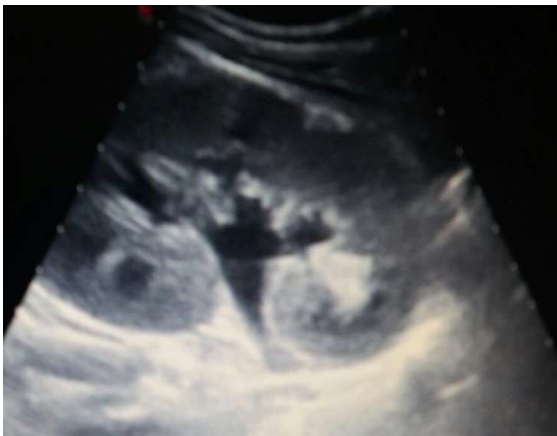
At hospital discharge, normal ultrasonography imaging.
